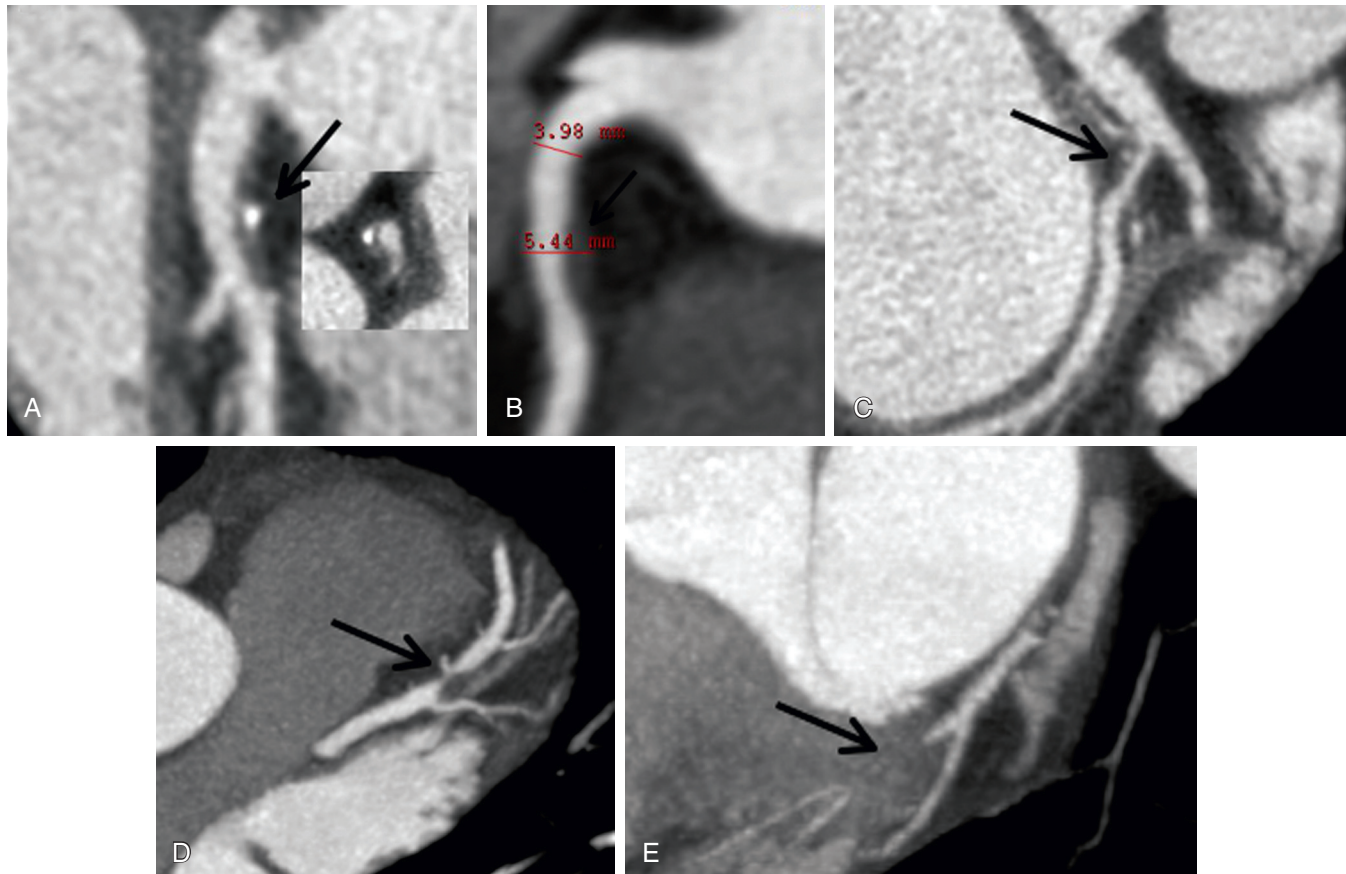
Coronary artery lesions of differing severity and grade as depicted on cardiac CT. A, Large mixed plaque without significant stenosis in the proximal left anterior descending coronary artery (curved multiplanar reformat), with outward arterial remodeling (arrow), as shown in the cross-sectional image (inset). B, Large noncalcified plaque with outward arterial remodeling in the right coronary artery with mild luminal stenosis (<25%). C, Moderate stenosis (50%) in the proximal left circumflex coronary artery with a mixed plaque (arrow). D, High-grade (>70%) stenosis of the mid-left anterior descending coronary artery with a noncalcified plaque (arrow). E, Total occlusion (arrow) of the distal left circumflex coronary artery.
